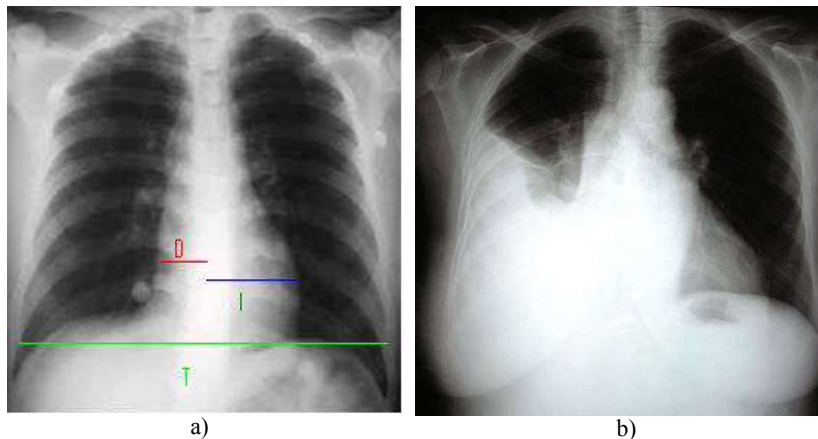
Parameters and anomalies in a thorax radiography to diagnose a cardiac insufficiency. a) Measurement of Cardiothoracic index, b) Right pleural edema.
